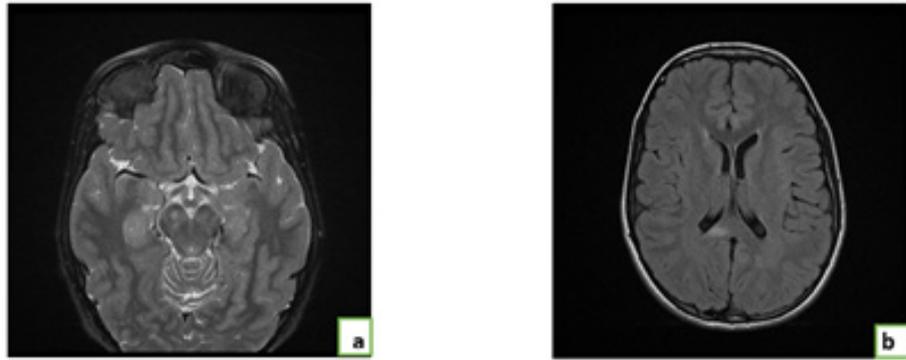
T2(a)and FLAIR(b)axial cup MRI showing signal abnormalities of the right cerebral peduncle, callous body spleen and left lenticular nucleus in hypersignal T2 and FLAIR in relation to "OBNI".
